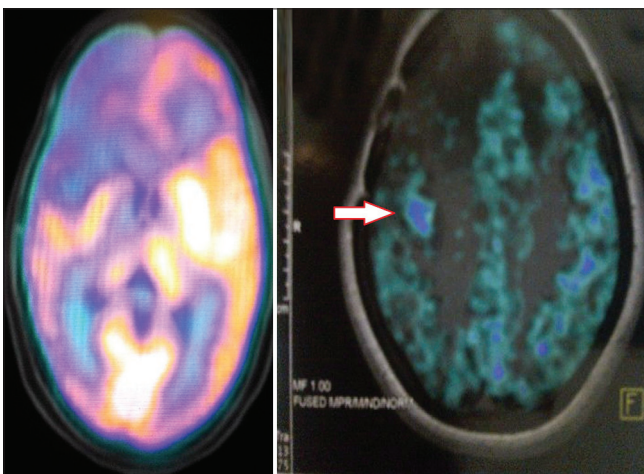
18-Fluoro deoxy glucose PET-MRI brain images (see arrow)
